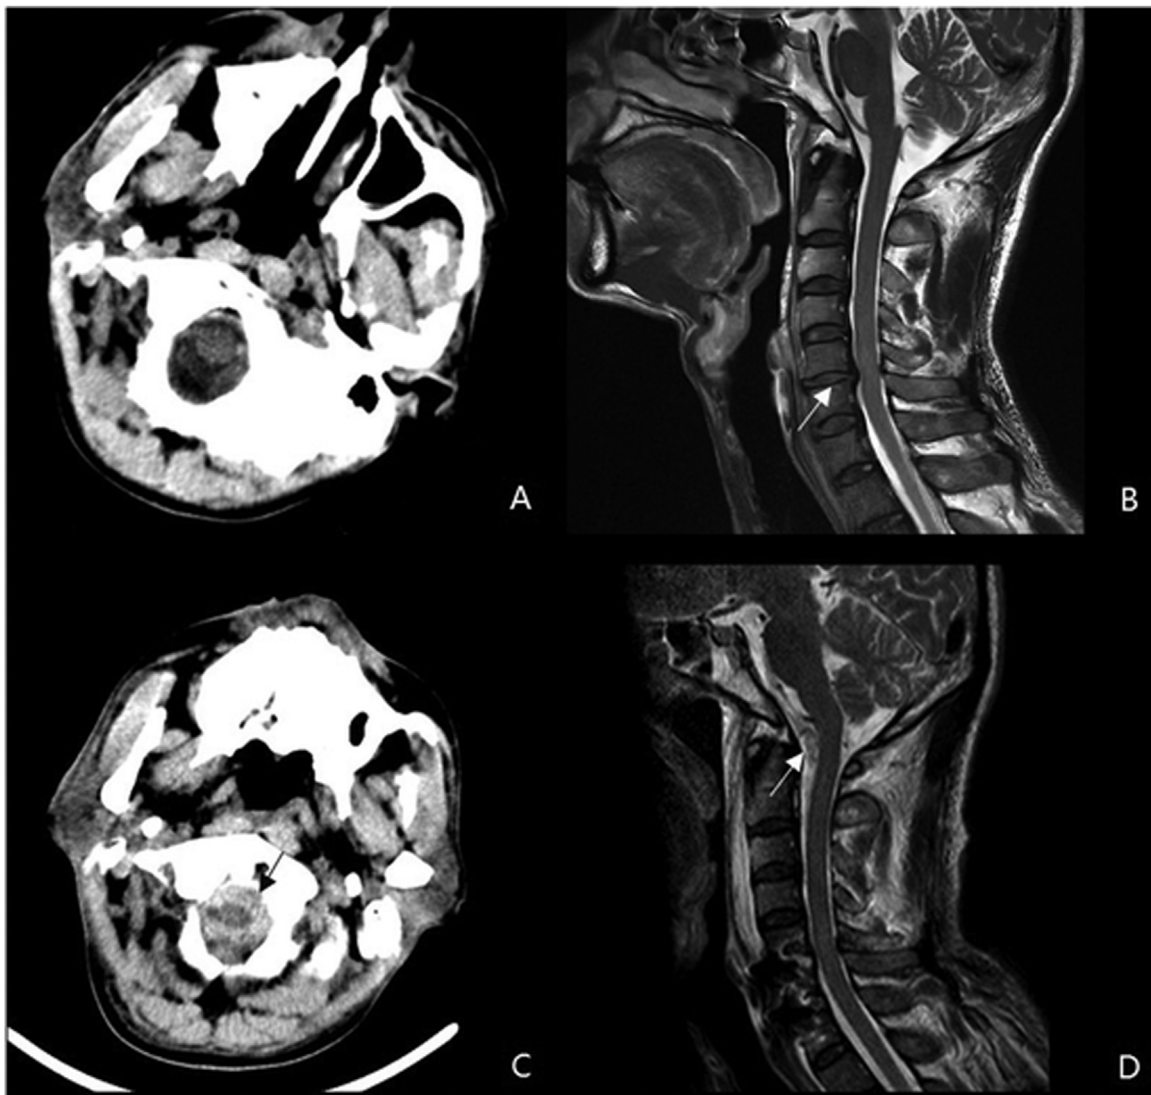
Preoperative magnetic resonance imaging (MRI) and computed tomography (CT) (A, B). Axial brain CT (A) showing normal area of medulla oblongata. Sagittal T1-weighted MRI of the cervical spine (B) demonstrating an extruded C5–6 and C6–7 intervertebral disc and spinal canal stenosis (arrow). Postoperative MRI and CT at 22 h after spinal surgery (C, D). Axial brain CT (C) and sagittal T1-weighted MRI of the cervical spine (D) demonstrating medulla oblongata ventral acute subarachnoid hemorrhage (arrows).
